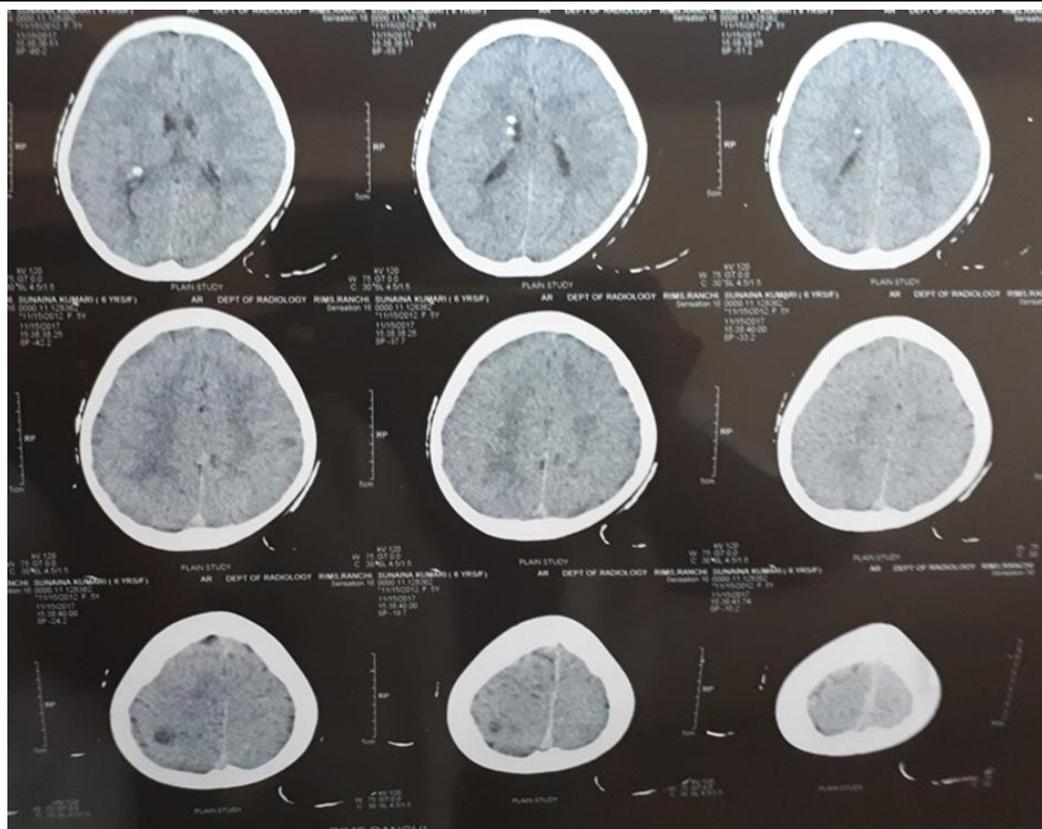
CT Brain showing Subependymal nodules in right lateral ventricle and right parieto-occipital tubers (Case 2)
